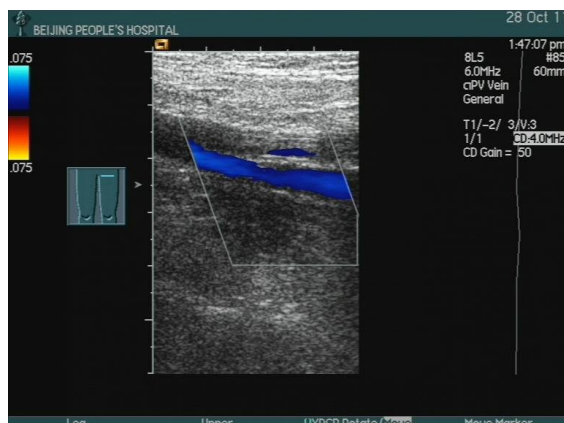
The ultrasonic blood flow imaging of the left superficial and deep femoral veins induced by oral administration of CBZ. The upper short and thin blue strip blood flow imaging showed a small amount of recanalization in the left superficial femoral vein after thrombosis, and the lower long and wide blue strip blood flow imaging showed the quite patency of the left deep femoral vein
